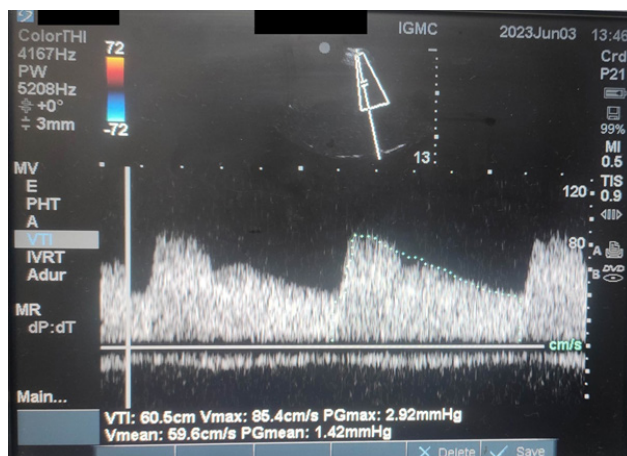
spectral waveform obtained after transcranial color coded duplex ultrasonography of the middle cerebral artery (MCA). The parameter Vmax corresponds to the peak MCA flow velocity (cm/s). The parameter Vmean corresponds to mean MCA flow velocity (cm/s).
